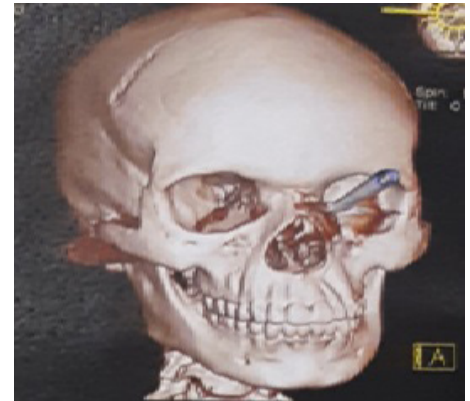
3D CT scan showing foreign body involving orbital, naso-orbitoethmoid and maxillary region causing fracture of the right zygomatic arch
